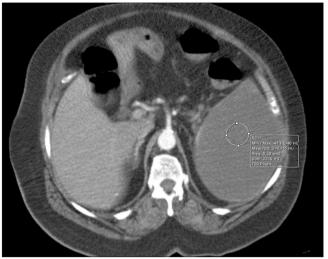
Contrasted CT image of abdomen after three weeks of the colonoscopy: Hematoma has a tendency to become chronic and its average density was measured as 3 HU.
